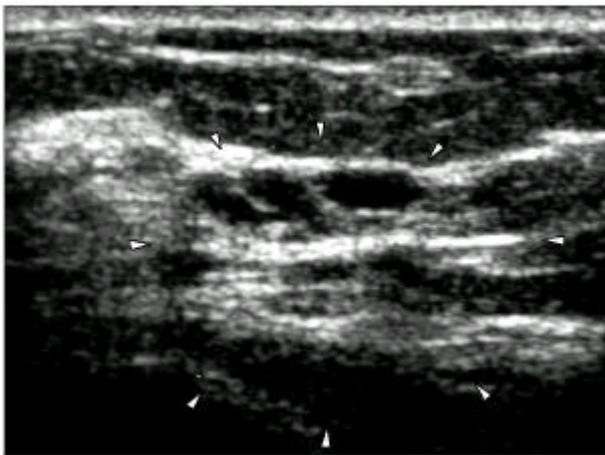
Ultrasonographic finding shows conglomerated several anechoic cysts without posterior acoustic shadowing.
